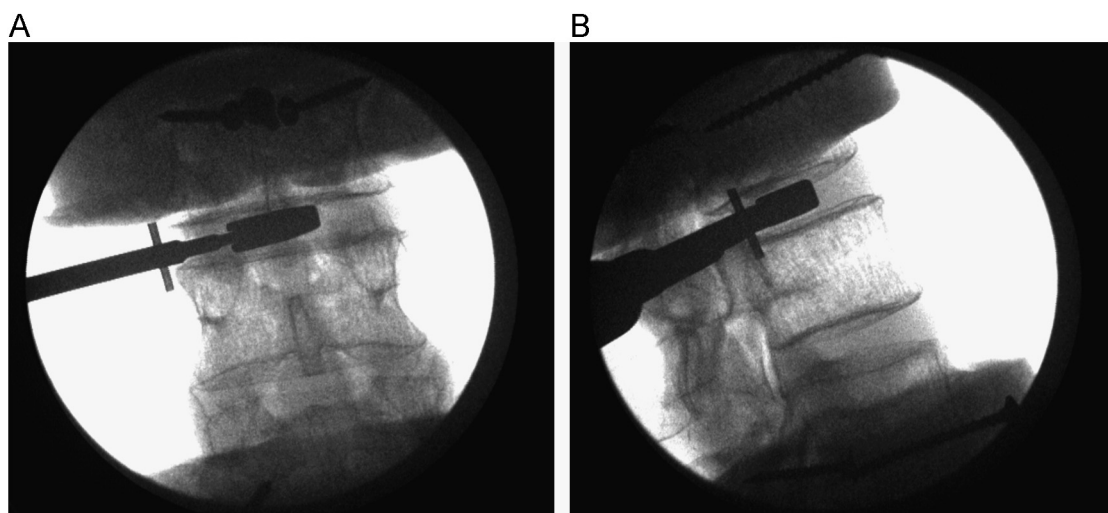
Radiographic image of trial spacer for sizing of the nucleus implant in (A) AP and (B) lateral views.
